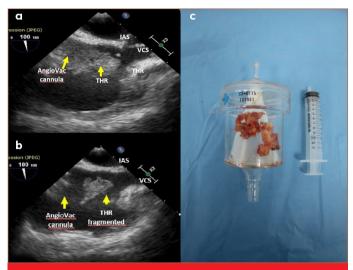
a and b: Two-dimensional transthoracic echocardiographic images of thrombus suction. c: Thrombus material extracted into the AngioVac filter (AngioDynamics Inc., Latham, NY, USA)
